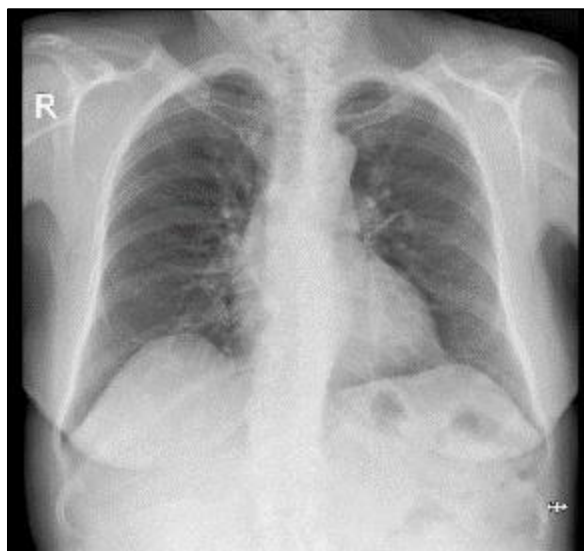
Chest radiograph within normal limits; no acute pulmonary process identified
